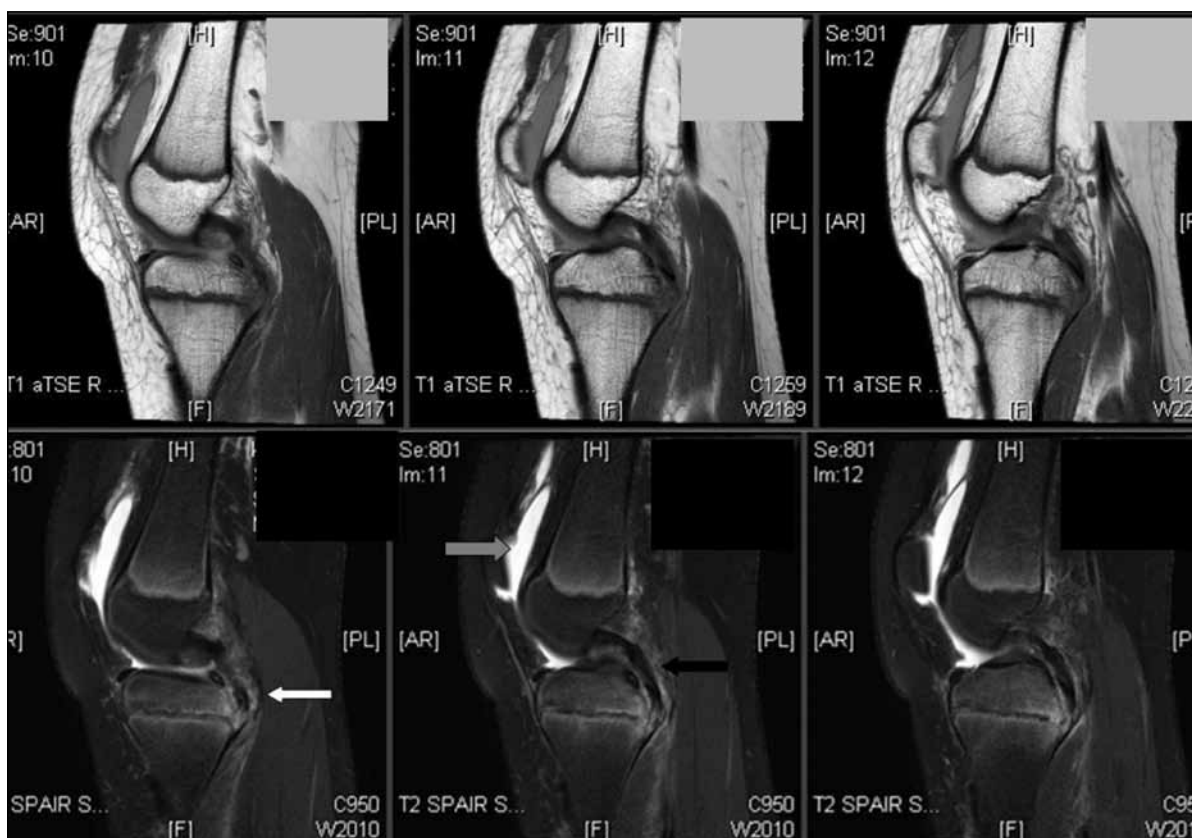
Serial T1-weighted and T2-weighted magnetic resonance imaging showing gross knee effusion (grey arrow), heterogeneity of the avulsion fracture (white arrow) and intact posterior cruciate ligament (black arrow)
